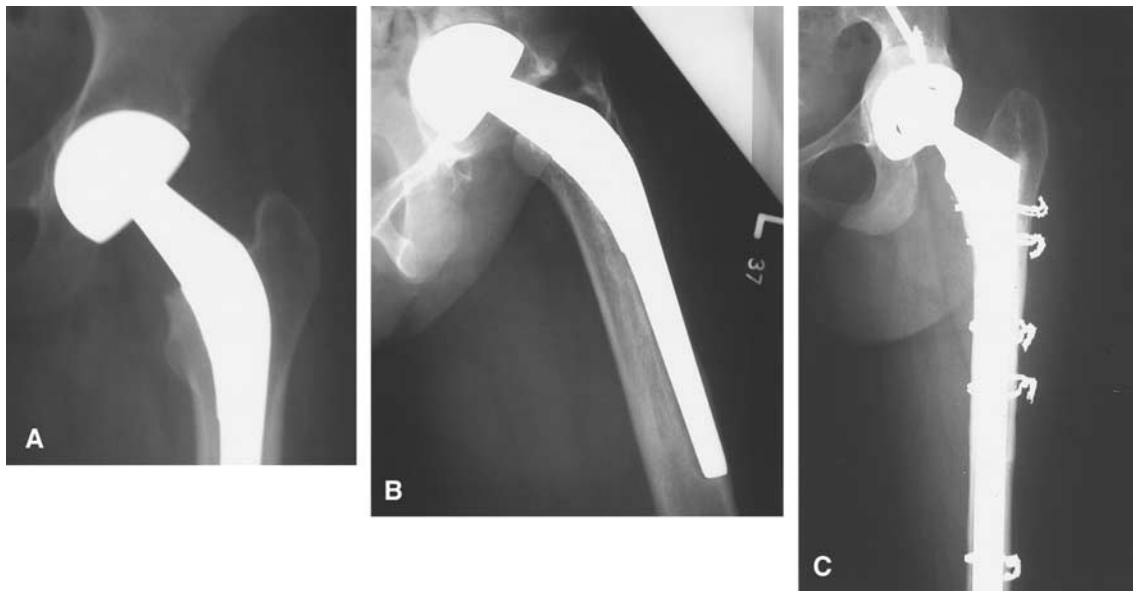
Aseptic femoral loosening and acetabular osteolysis associated with patch porous-coated stems. (A) Early postoperative radiograph shows a well-fixed component in acceptable alignment. (B) Prosthetic failure with stem migration and cortical perforation and extensive acetabular lysis. (C) Conversion THA with bulk allograft acetabular reconstruction and long-stem revision with strut allograft.
